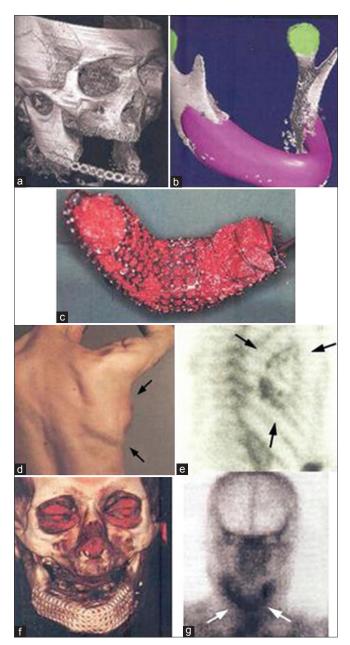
Three-dimensional CT scan of size defect (a) and CAD plan of ideal mandibular transplant (b). Titanium cage filled with bone mineral block infiltrated with recombinant human BMP7 and bone-marrow mixture (c). Dorsal view of mandibular replacement 3 weeks after implantation (d). Skeletal scintigraphy of implant (e). Three-dimensional CT scan after transplantation of the bone replacement with enhancement of soft tissue (f) and repeat skeletal (g) scintigraphy with tracer enhancement showing continued bone remodelling and mineralisation (arrows)
